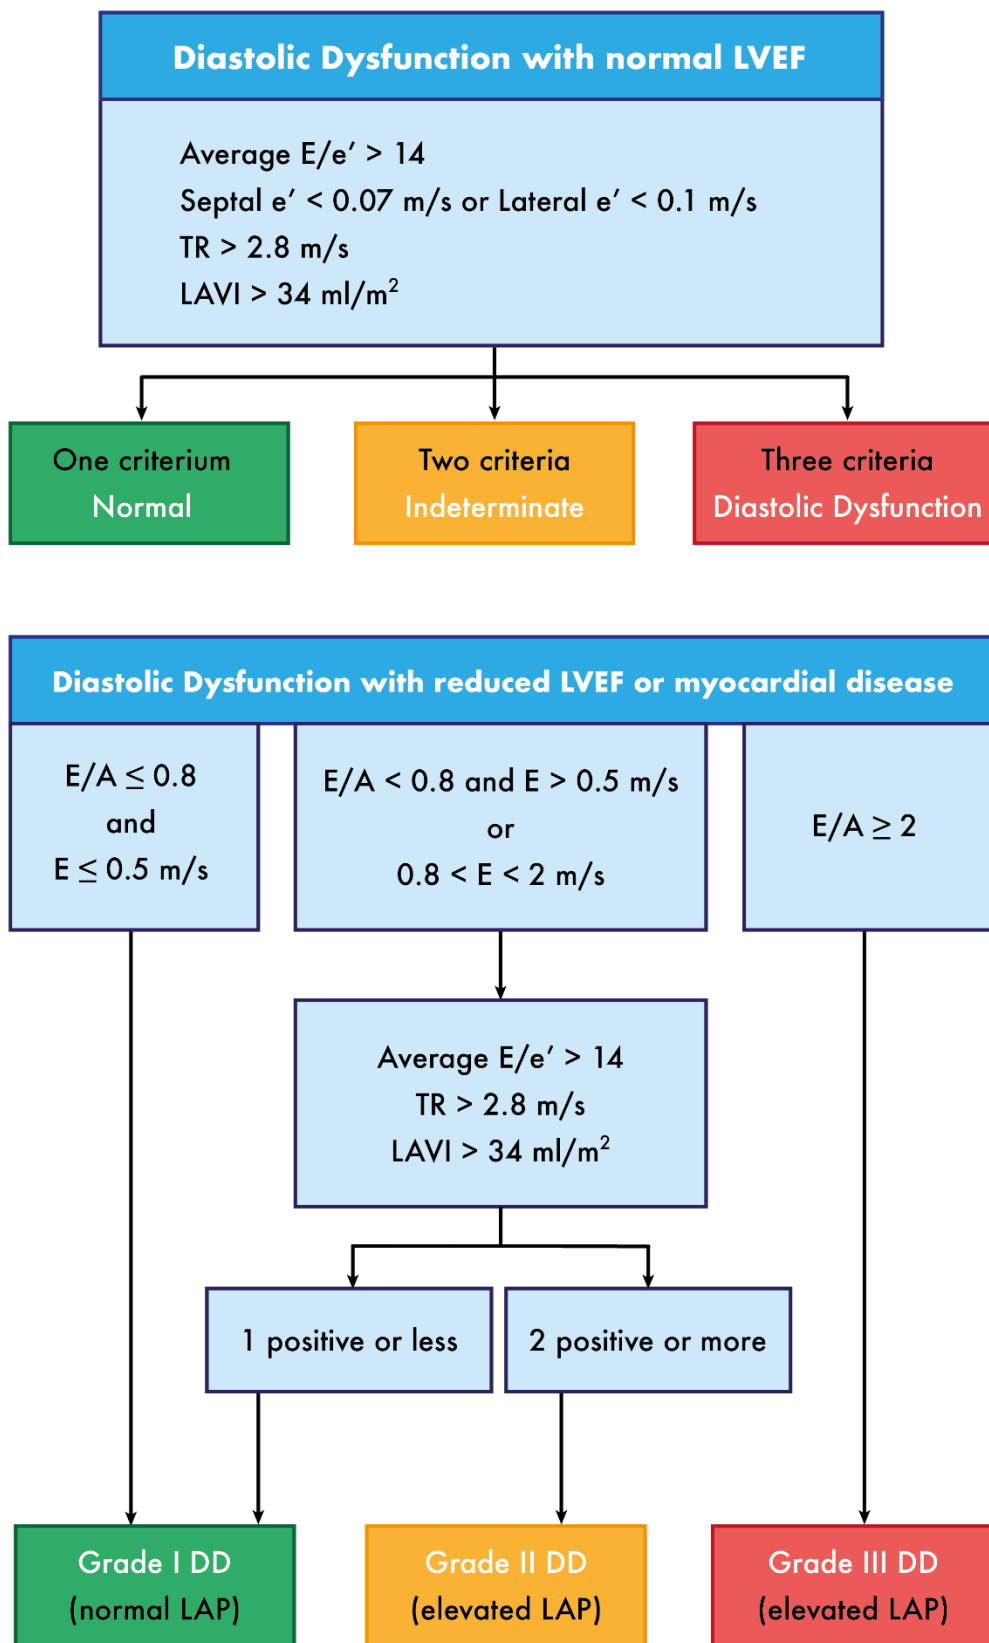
Diagnostic algorithm for DD in patients with normal or reduced LVEF/myocardial disease as per the 2016 guidelines of the American Society of Echocardiography [71]. LVEF – left ventricular ejection fraction, TR – tricuspid regurgitation jet velocity, LAVI – left atrial volume index, LAP – left atrial pressure.
